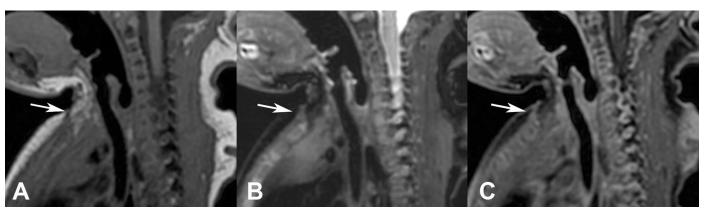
A two-day old girl with congenital midline cervical cleft. FINDINGS: Magnified sagittal T1-weighted (A), fat-saturated T2-weighted (B), and post-gadolinium fat-saturated T1-weighted (C) images show a T1 hypointense, T2 hyperintense, and peripherally-enhancing cranio-caudally oriented tract (white arrow). The tract courses from the skin in the midline at the base of the neck toward the manubrium of the sternum. TECHNIQUE: 3.0 Tesla MRI (GE Discovery) Image A: Sagittal T1 TR/TE -600/8 ms, 1.5 mm slice thickness, noncontrast; Image B: Sagittal T2 TR/TE - 3000/62 ms, 1.5 mm slice thickness, noncontrast; Image C: Sagittal T1 TR/TE - 600/8 ms, 1.5 mm slice thickness, Gadolinium contrast 0.2 mL/kg.
